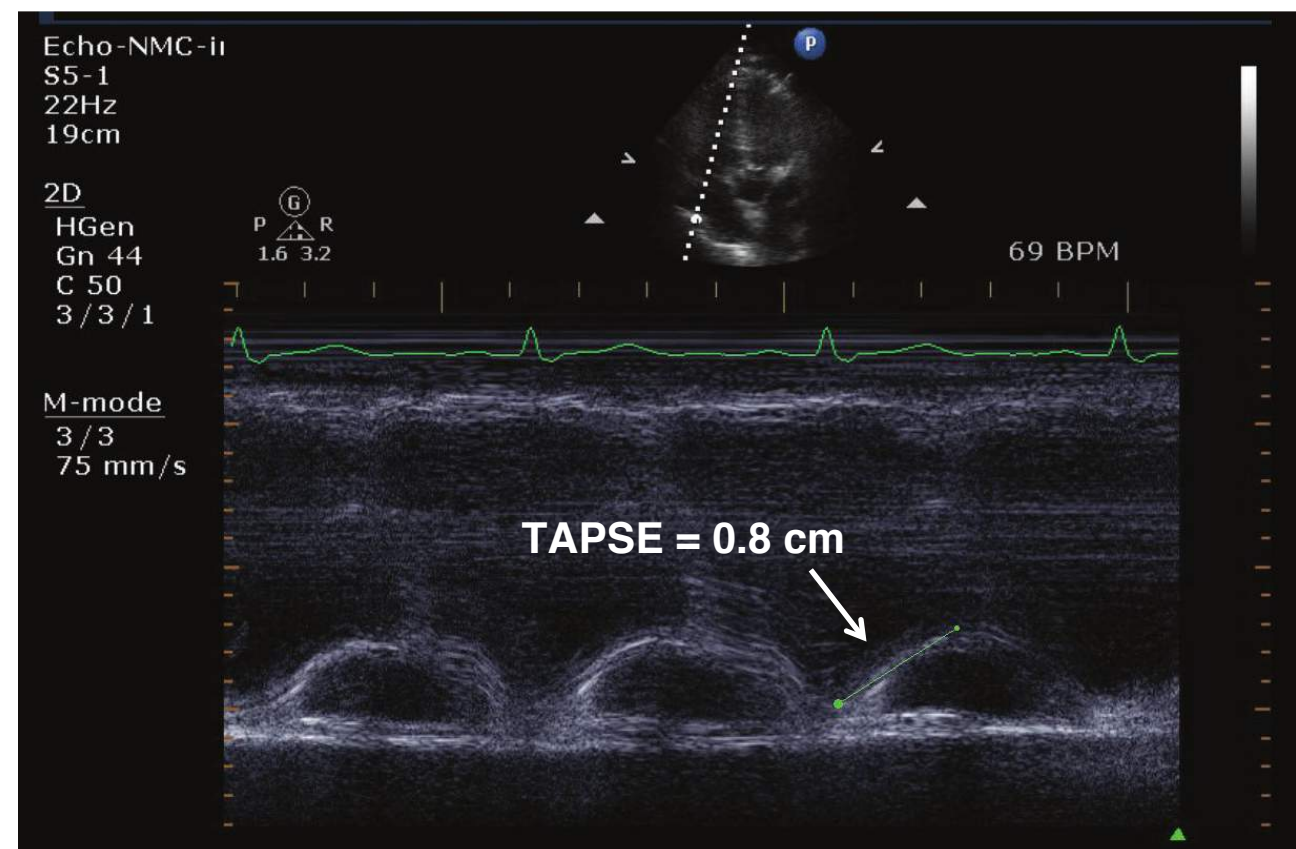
Measurement of TAPSE through the lateral annulus of the right ventricle using M-Mode in the apical four-chamber view. The TAPSE is 0.8 cm in this patient, demonstrating significant right ventricular dysfunction.
